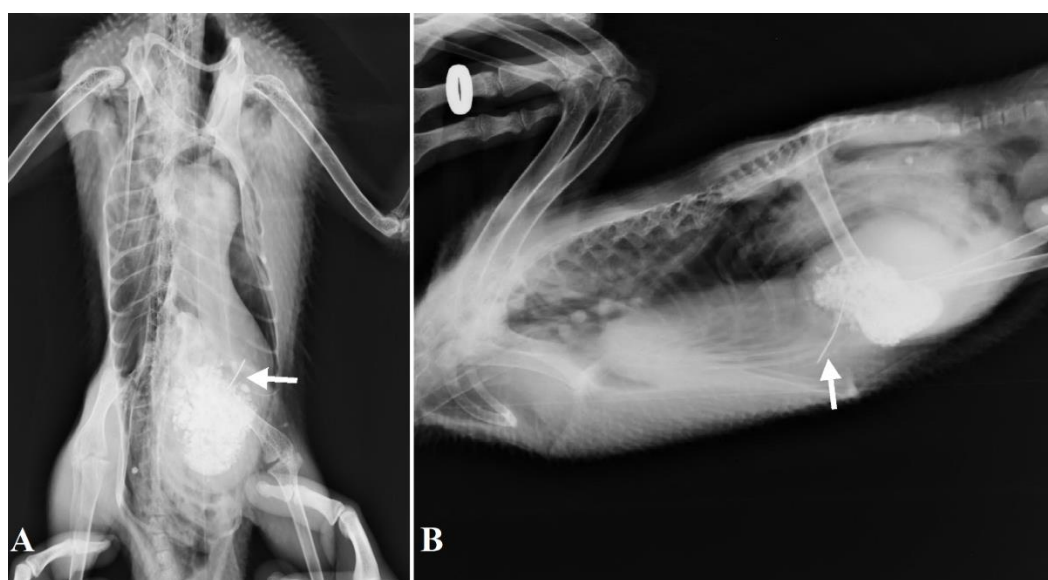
A 2.7 cm metallic needle was observed in the anatomical region of the gizzard in ventrodorsal (A) and lateral (B) radiographs. The arrow indicates the needle's location.
